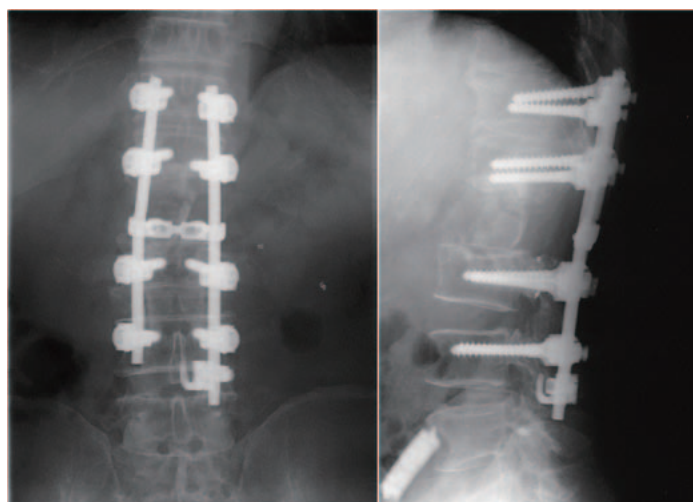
X-ray images at initial examination; A-P view (a) and lateral view (b).
